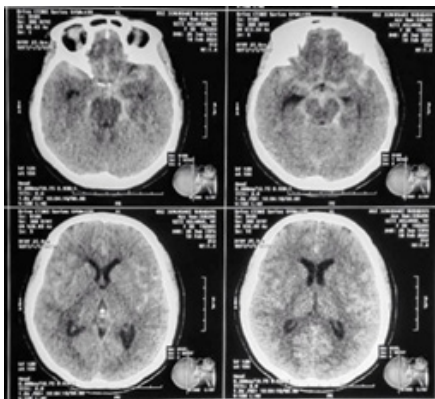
Head CT Scan Shows SAH In The Basal Cistern And Sulci Of The Right And Left Frontotemporoparietal Lobes
